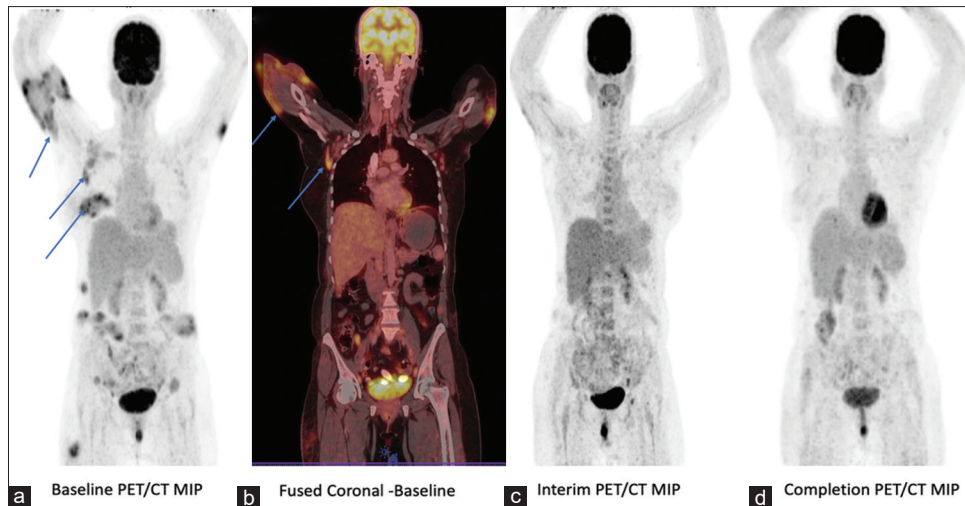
(a) Maximum intensity projection image of the whole body of baseline positron emission tomography/computed tomography, revealing multiple fluorodeoxyglucose avid subcutaneous and cutaneous soft-tissue thickening, soft-tissue thickening in the right breast parenchyma with axillary and pelvic lymphadenopathy. (b) Fused coronal positron emission tomography/computed tomography show similar changes. (c and d) Interim and end of treatment positron emission tomography/computed tomography shows partial and complete metabolic response, respectively
